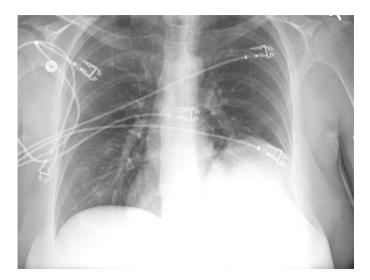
A 62-year-old woman with chest pain. Anteroposterior chest X-ray demonstrates mass inseparable from left hemidiaphragm and cardiac border (arrow). No evidence of adenopathy is seen.
